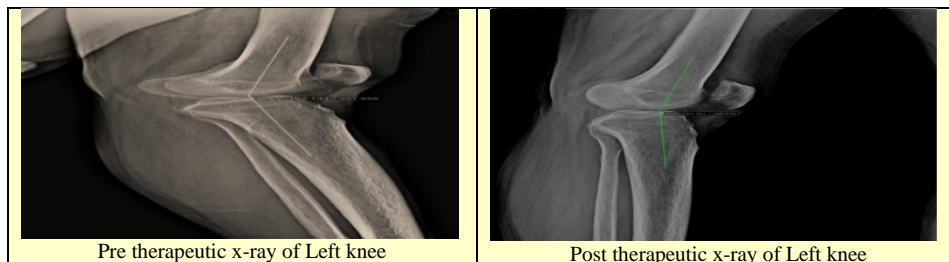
Shows Patient 2 Pre vs. Post Therapeutic X-ray of left Knee
